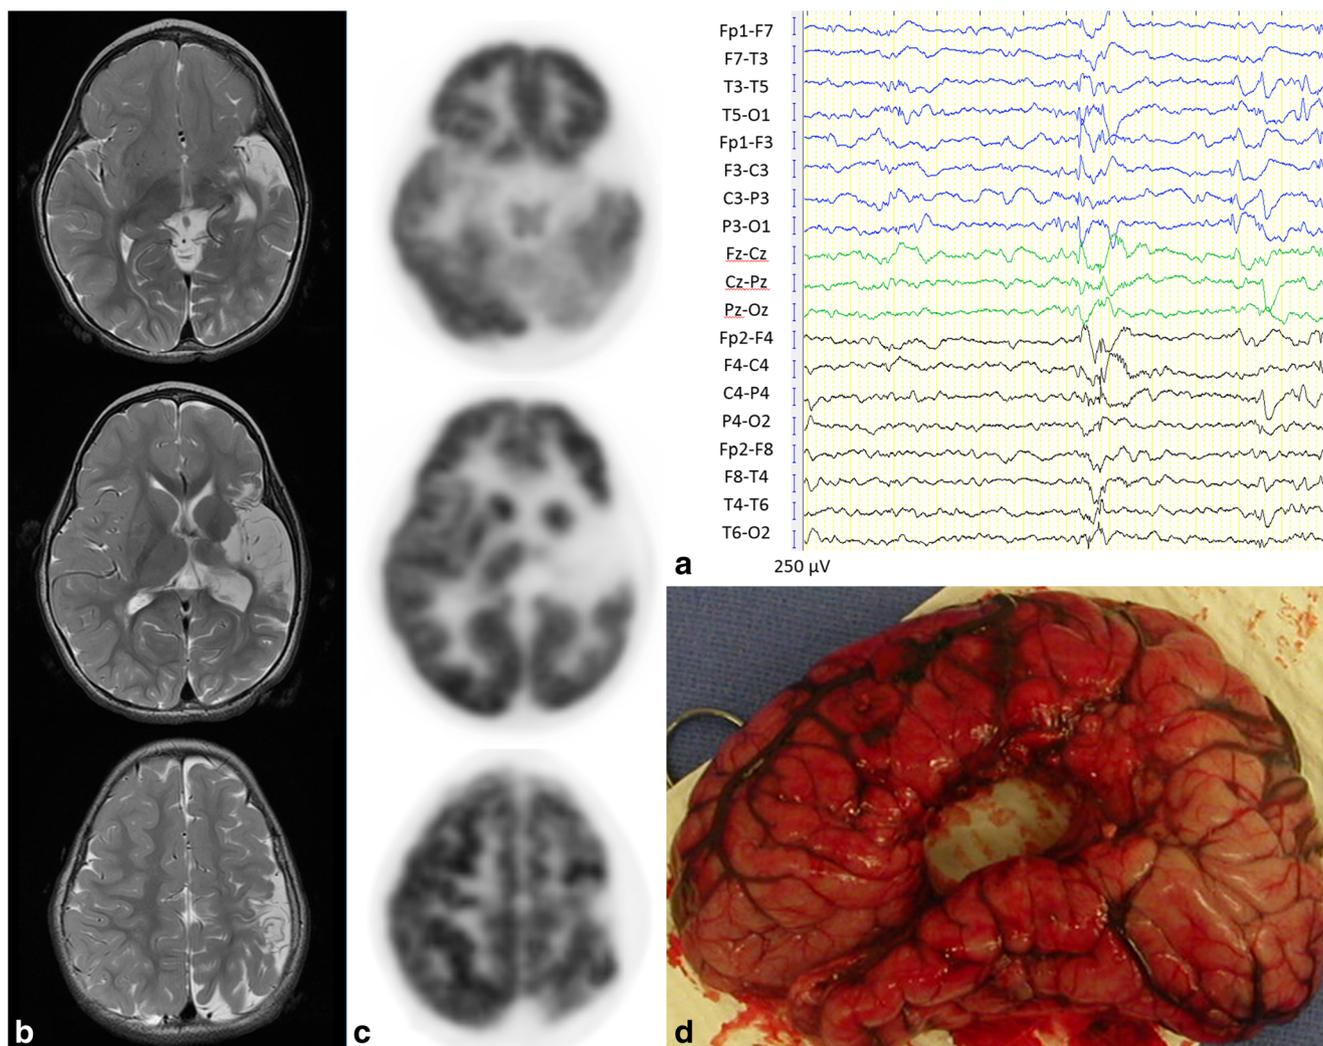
A 24-month-old girl underwent left hemispherectomy. a Preoperative EEG showed frequent interictal spike-wave discharges in the left hemisphere with and without secondary bilateral synchrony. b Preoperative axial T2 MRI
